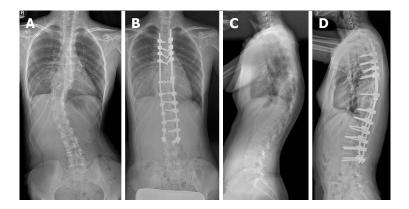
Plain radiography of pre- and postoperative whole spine anterior-posterior view (A and B) and lateral view (C and D).
